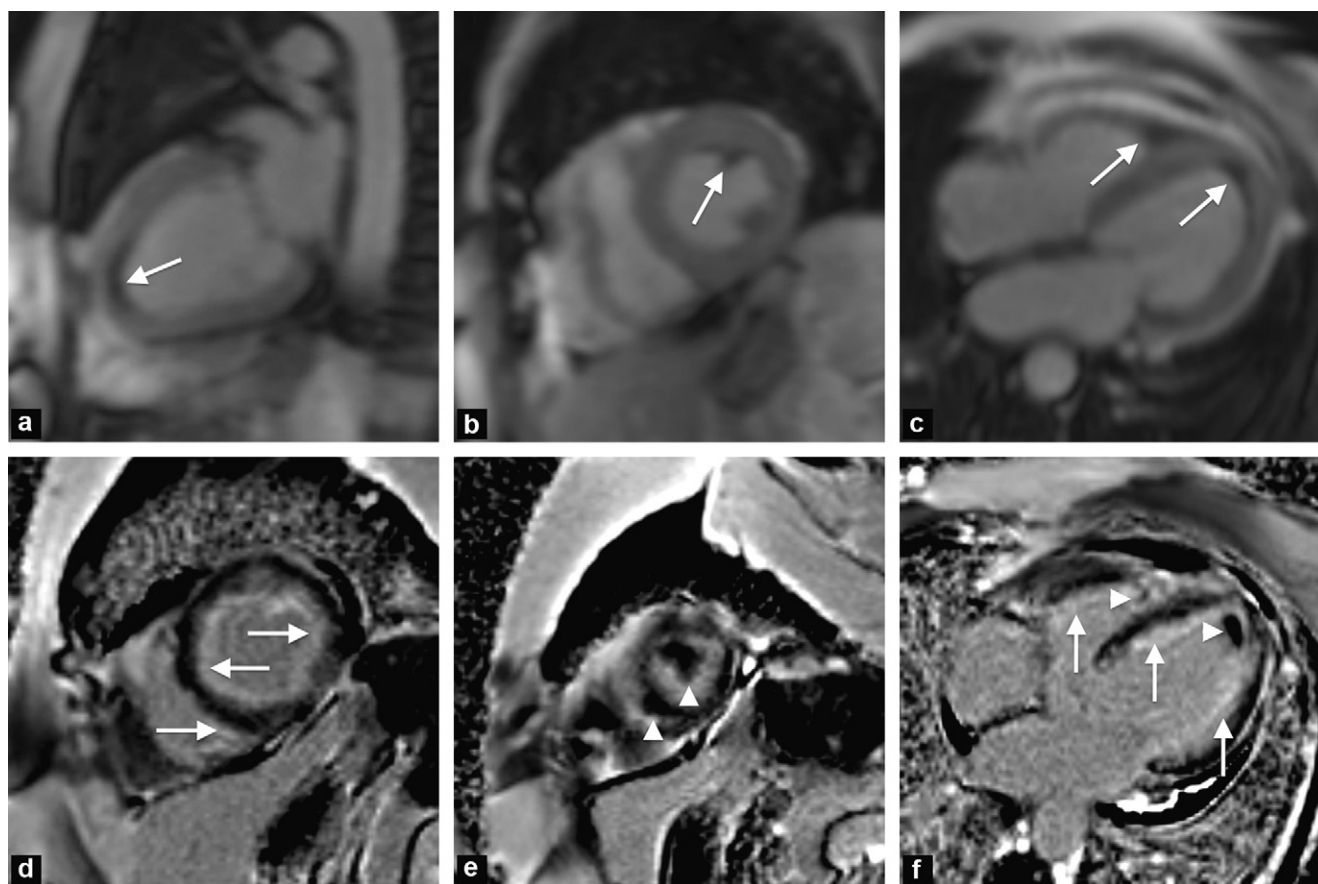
Cardiac MRI: first passage perfusion sequences (a, b, c) showing hypoperfusion as a hyposignal in the apices of the ventricles (arrows); late enhancement sequences (d, e, f) showing diffuse subendocardial enhancement (arrows) associated with the presence of thrombi in the apices of the ventricles (arrowheads).
